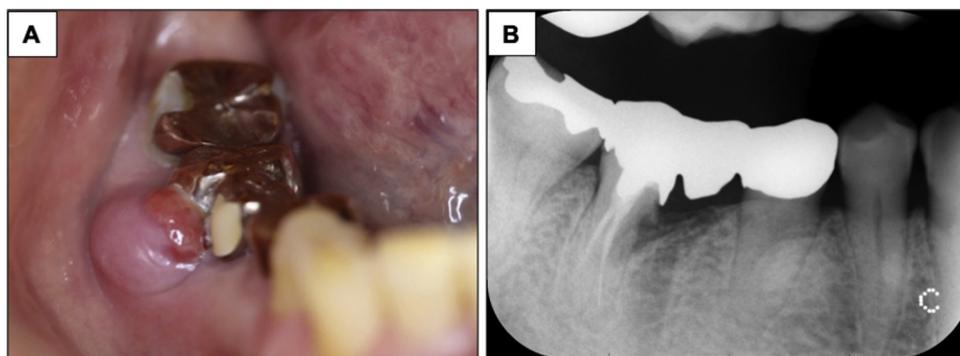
A: Intraoral photo and dental x-ray image at first visit. The gingiva of the mandibular gingival molar region was swollen with hemisphere-shaped masses covered with smooth and reddish mucosa. B: On the dental X-ray image, there was no obvious abnormal finding.
